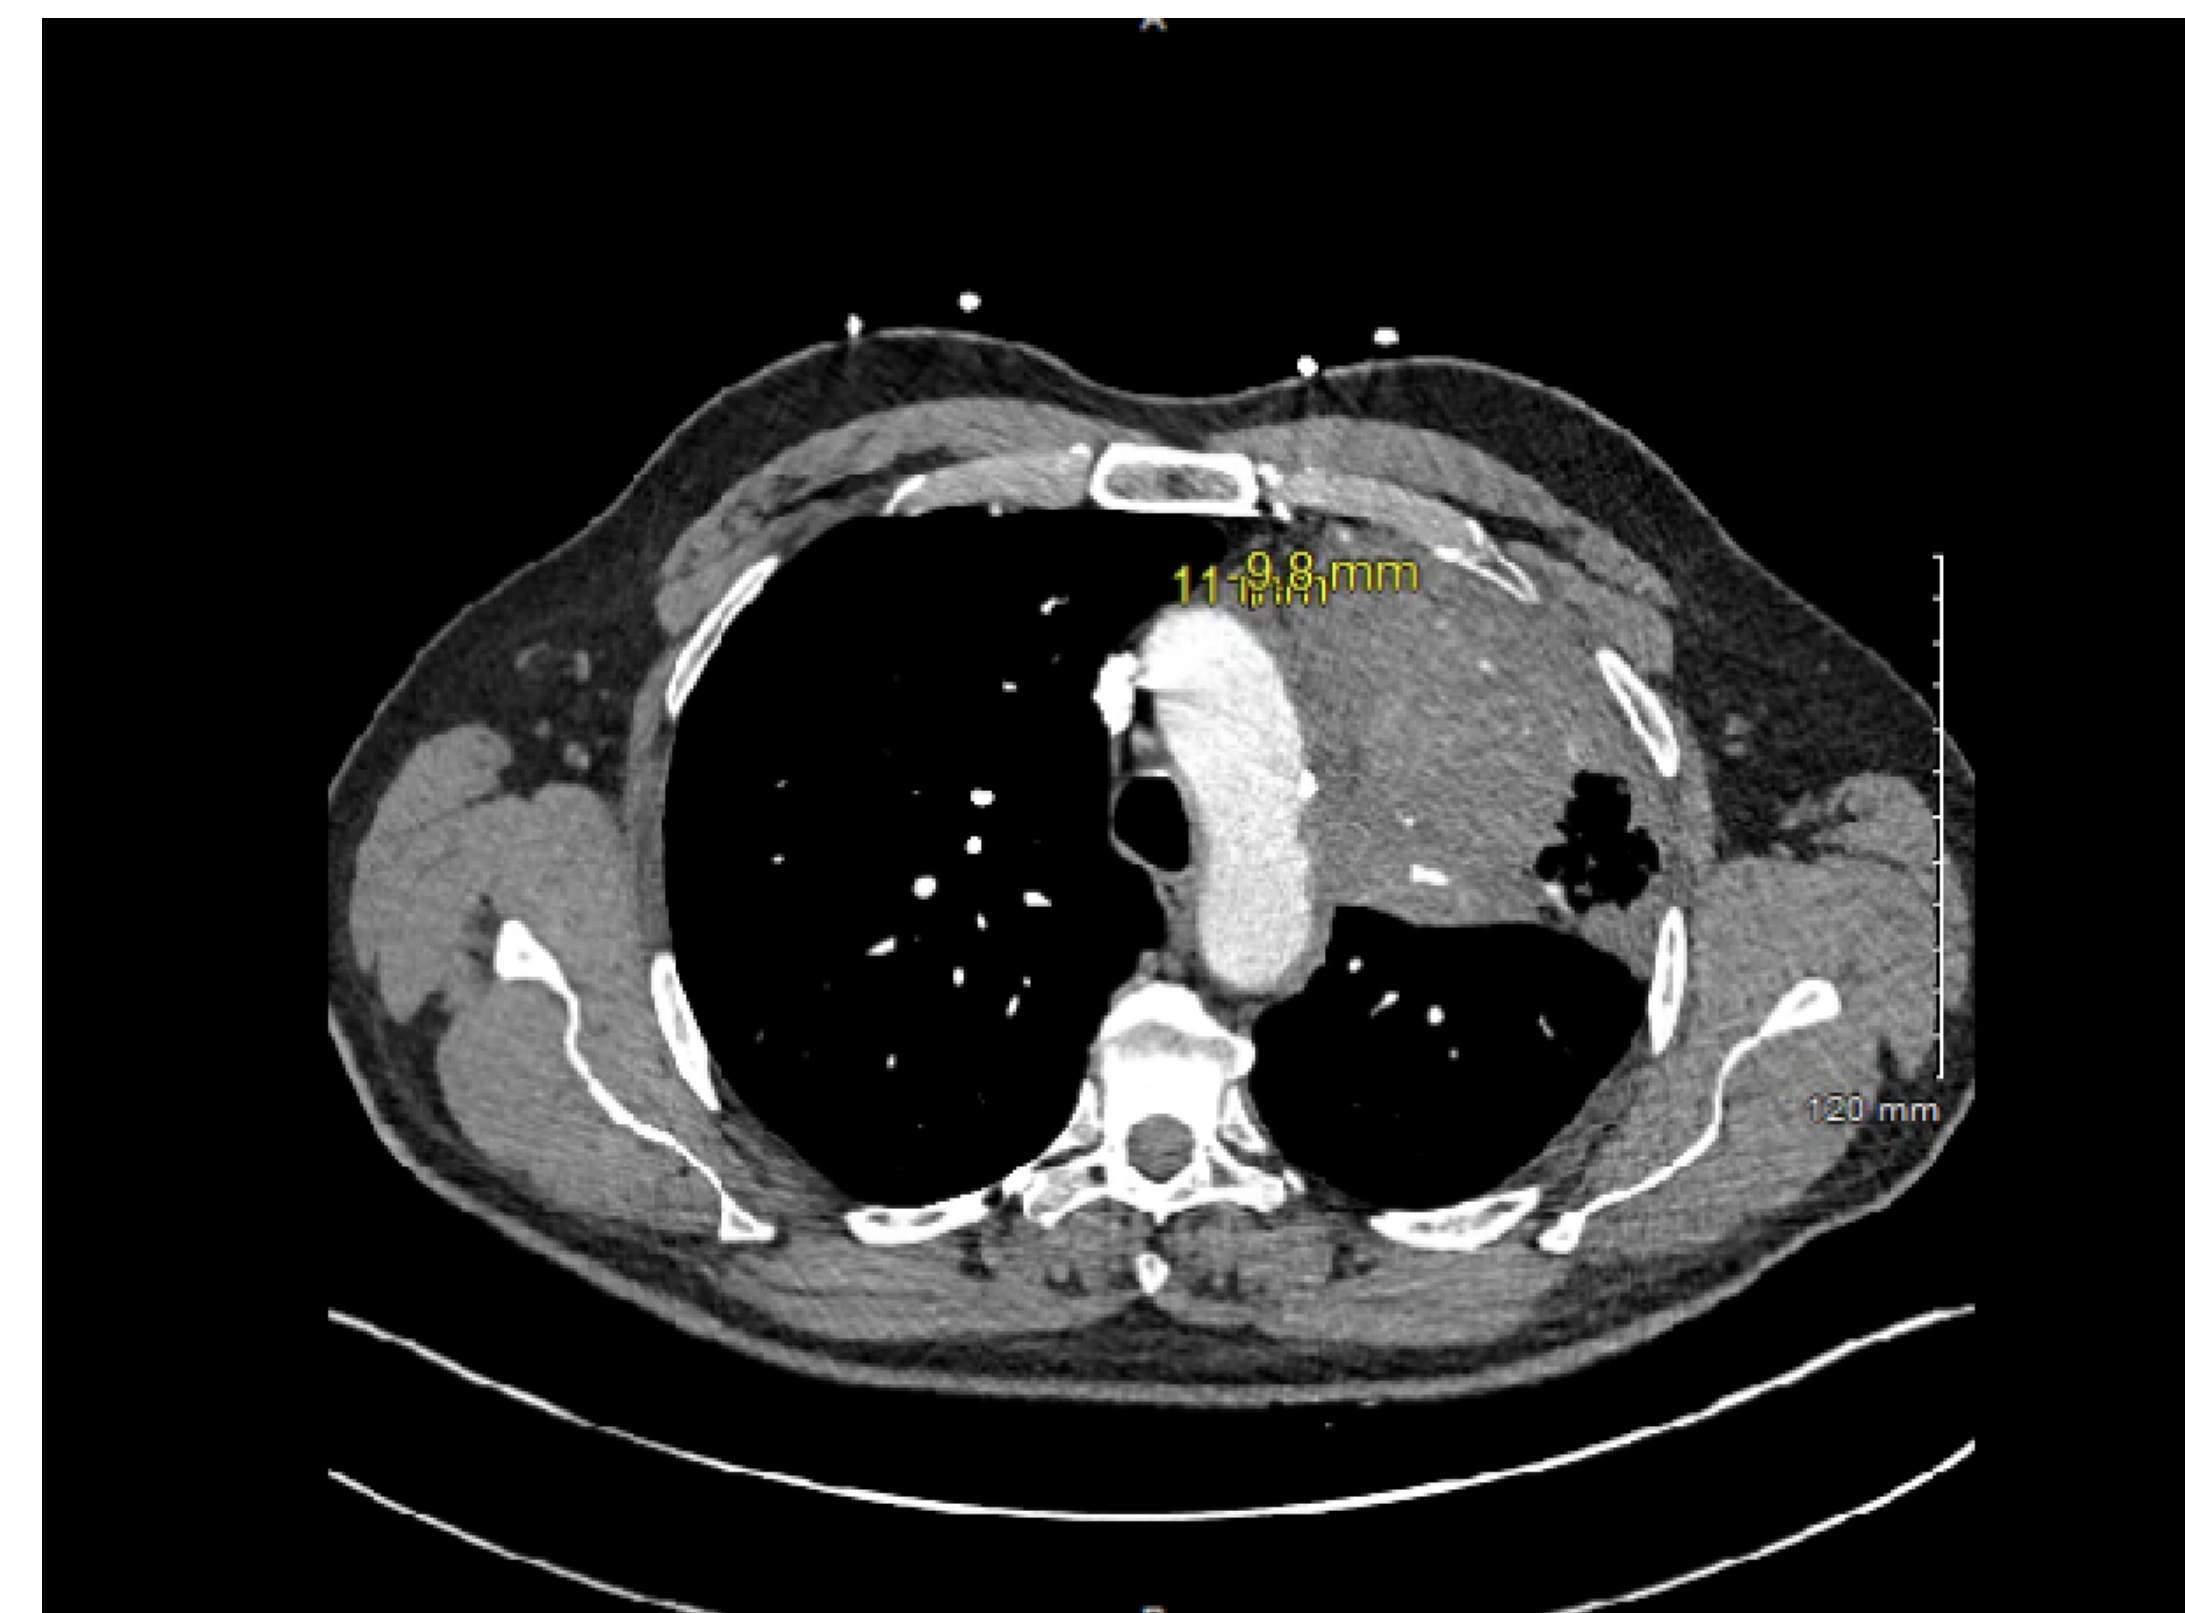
CTA of the chest showing the left upper lobe post obstructive pneumonia
